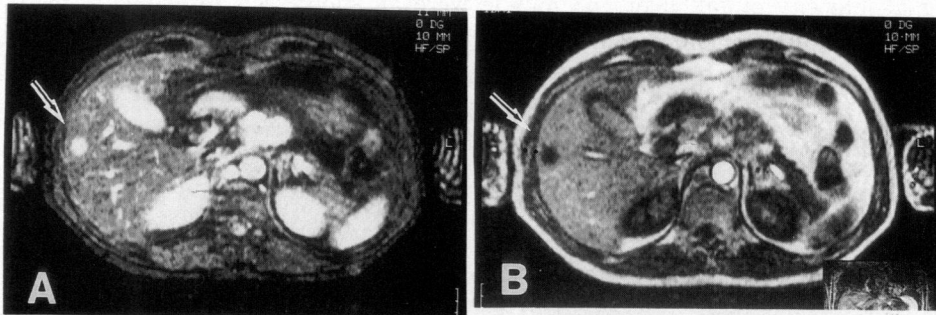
MR imaging of hepatocellular carcinoma (Fig. 9) by STIR method.
